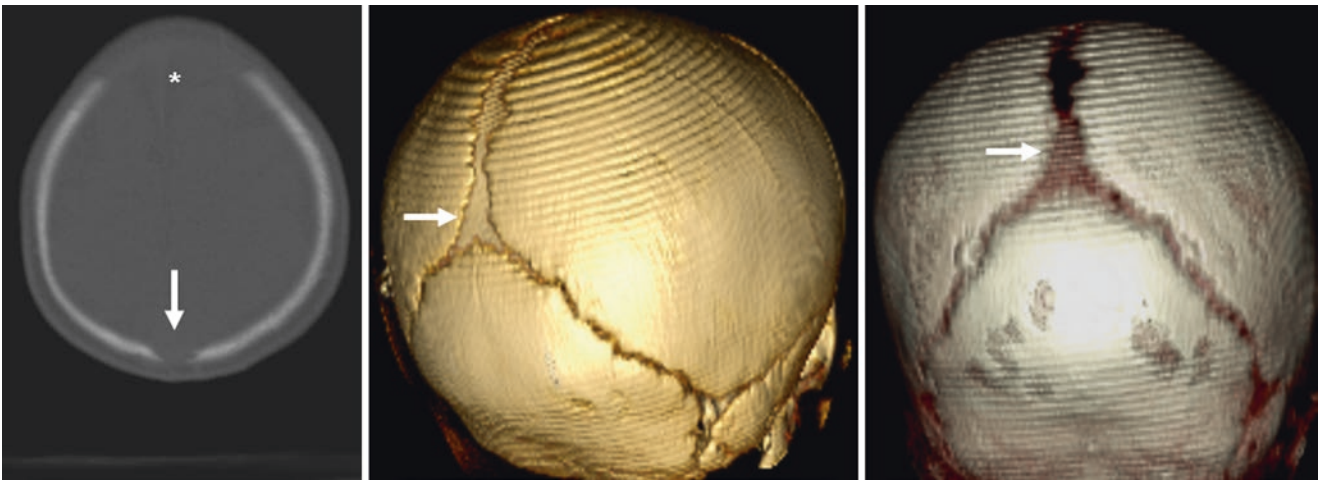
A 3 month old with a small, patent PF (*arrow*) and AF (*asterisk*). 3D VR CT RPO (*middle*), and posterior/PA (*right*) views are also provided
